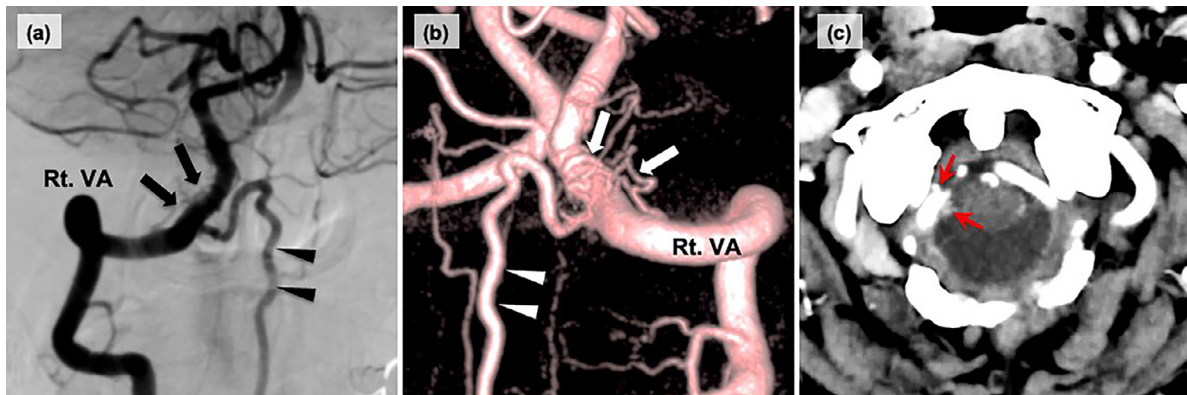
The right vertebral angiogram. The A-P view (A) and posterior view of the 3D-DSA (B) demonstrate an arteriovenous fistula at the craniocervical junction fed by right meningeal arteries (arrows) from the right VA, draining into the dilated ASV (arrowheads). The 4DCTA, axial view (C) reveals fistula points which locate around the site of the dural penetration of the right VA (red arrows). A-P, anterior-posterior; 3D-DSA, 3-dimensional digital subtraction angiography; VA, vertebral artery; ASV, anterior spinal vein; 4DCTA, 4-dimensional computed tomography angiography (Color version of figure is available online).
